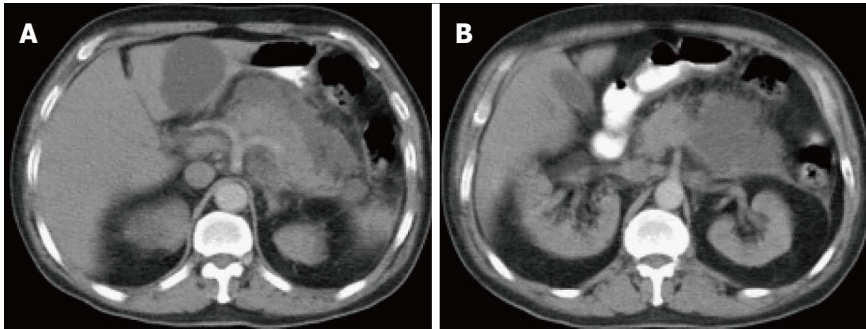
Acute interstitial edematous pancreatitis and acute peripancreatic fluid collections. A-B: Axial CT scan during the portal venous phase. The pancreas is mildly thickened and demonstrates mildly heterogenous enhancement, reflective of edema, in keeping with acute interstitial edematous pancreatitis. There is a peri-pancreatic fluid with imperceptible wall in keeping with acute peripancreatic fluid collections.
